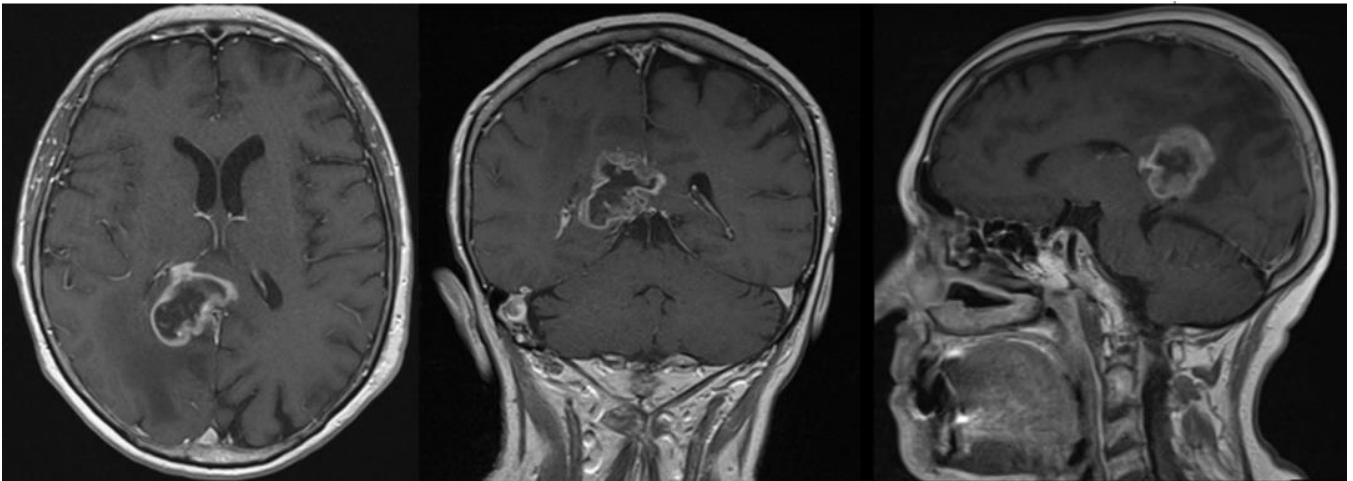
Post-gadolinium T1-weighted MRI GBM.
